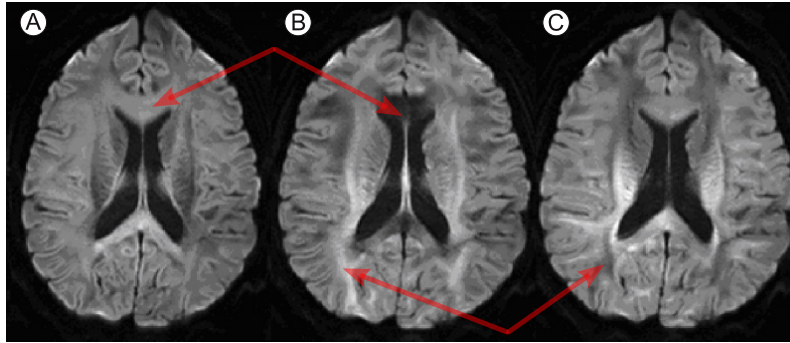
DWI images obtained, for the same slice, with diffusion gradients oriented in the Inferior-Superior (A), *i.e.* through the plane, Left-Right (B) and Anterior-Posterior (C) direction, respectively. (*image from <http://www.med.lu.se>*)
